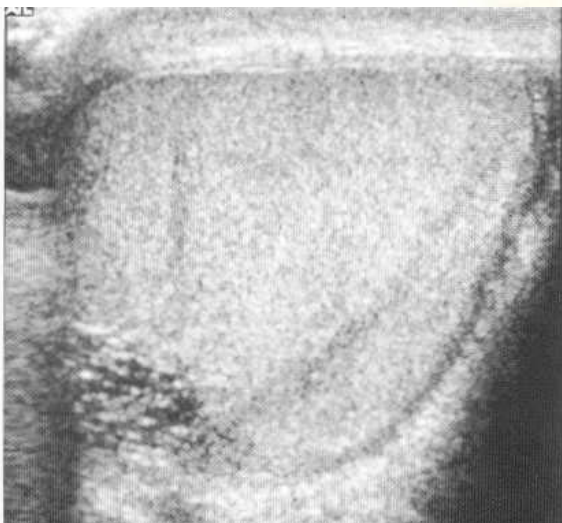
Ultrasound showing multiple tiny echo-free areas at the testicular hilum (dilated rete testis).
